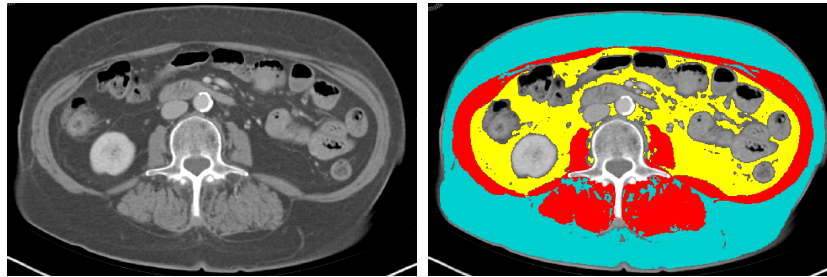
Representative L3 CT image of a patient (left) and colored version of the same image using sliceOmatic software (right). Red color shows muscle, yellow region represents VAT, and cyan shows SAT.
